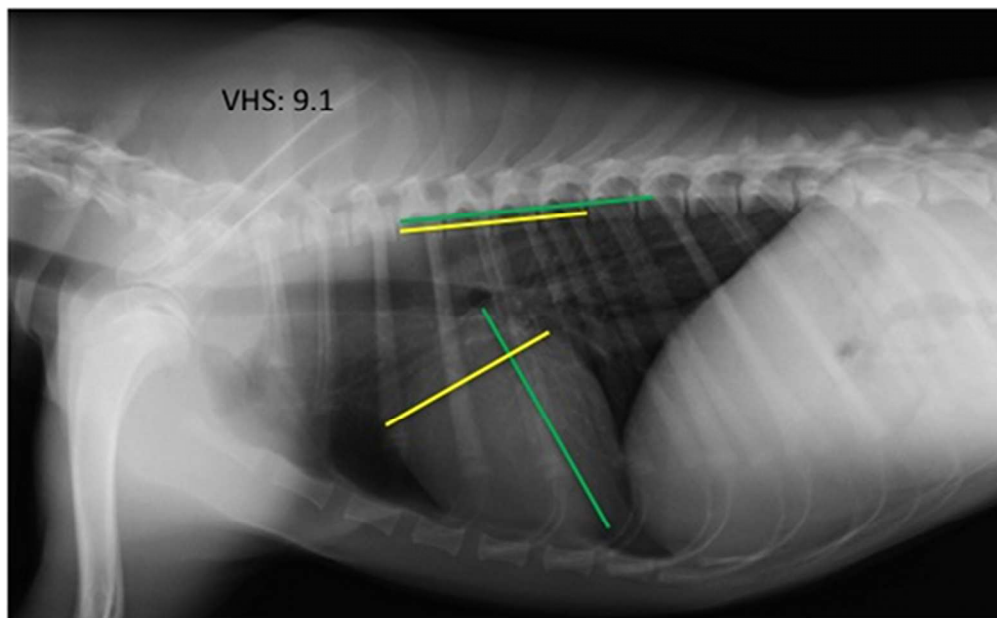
Right laterolateral thoracic radiograph. Buchanan Vertebral Heart Scale (Buchanan VHS), long (green line) and short (yellow line) cardiac axes are shown. VHS is expressed as total units of vertebral length: 9.1v after repositioning these measurements over the thoracic vertebrae beginning at the cranial edge of T4's vertebral body.
